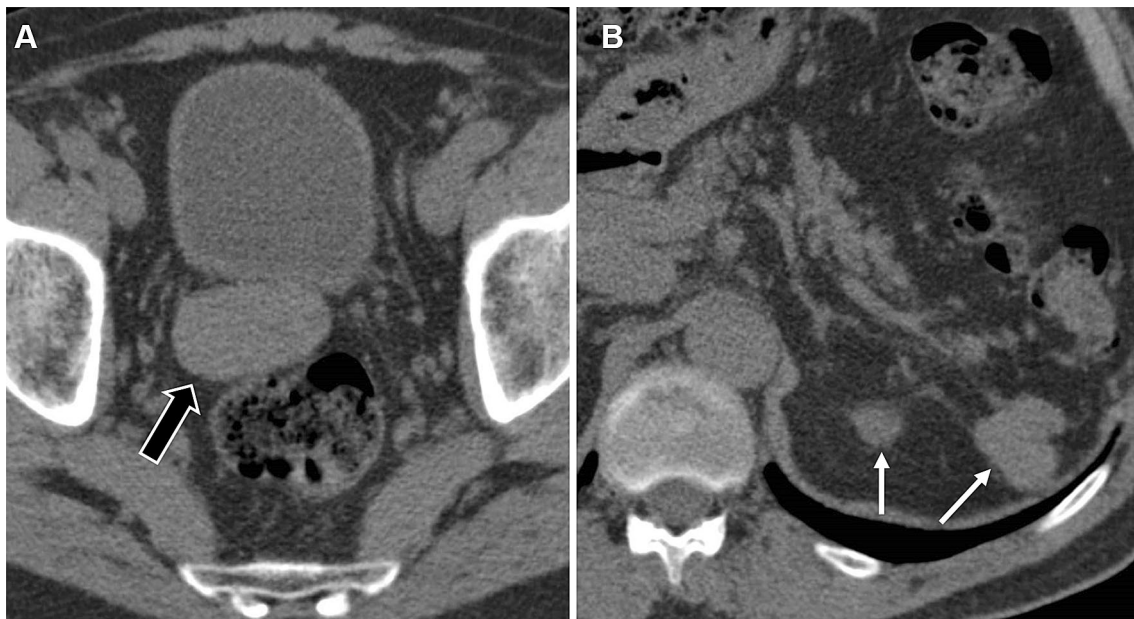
Axial non-contrast CT images of the pelvis (A) and abdomen (B) demonstrate a soft tissue mass in the pelvis (arrow, A) and soft tissue nodules in the left splenic bed (arrows, B).
